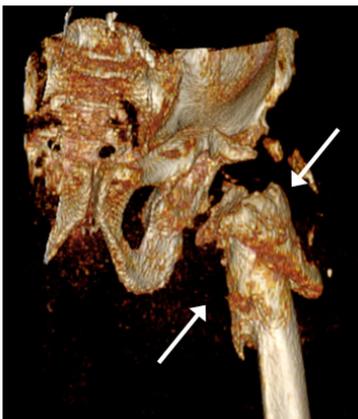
CT image showing new bone formation in a patient suffering from an infection around a hip prosthesis which has been removed (image courtesy: dr. H. C. Vogely, UMC Utrecht)
